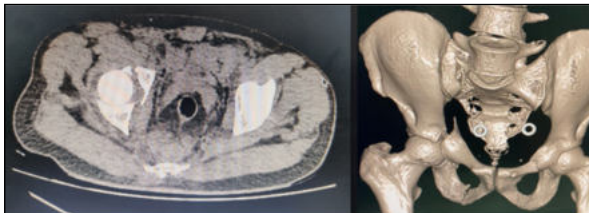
Preoperative CT scan 2D and 3D reconstructions
